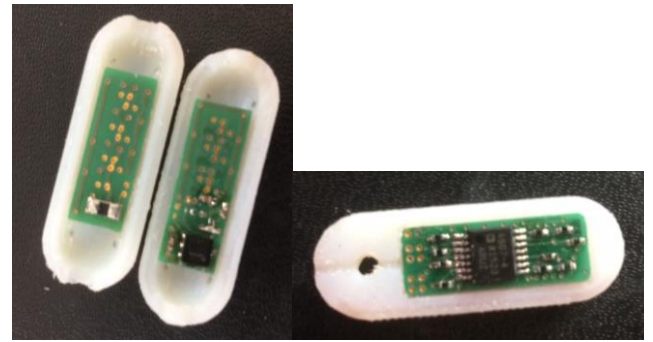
Thermocap (left) and Sonocap (right) with custom PCBs. Thermistor placement can be seen above and below the Thermocap PCBs, while the uppermost ultrasound transducer placement can be seen above the Sonocap PCB.
